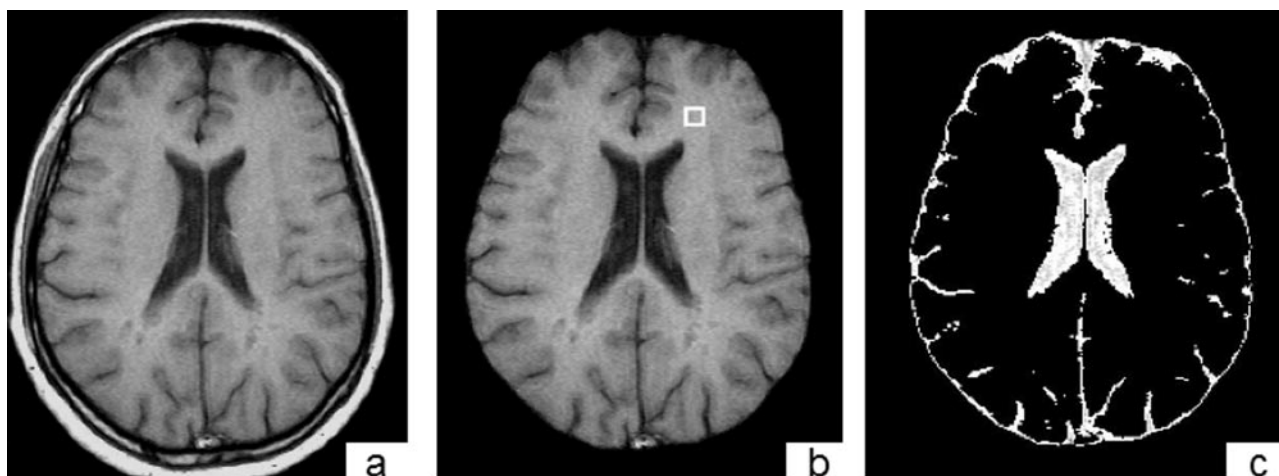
Semiautomated method of obtaining BPF. T1-weighted spin-echo 2D representative section from a patient with MS before masking (A), after masking the outer brain contour (B), and after thresholding (C). Panel B shows the region of interest in the normal-appearing white matter used for threshold determination. Adapted from Bermel et al (25).
